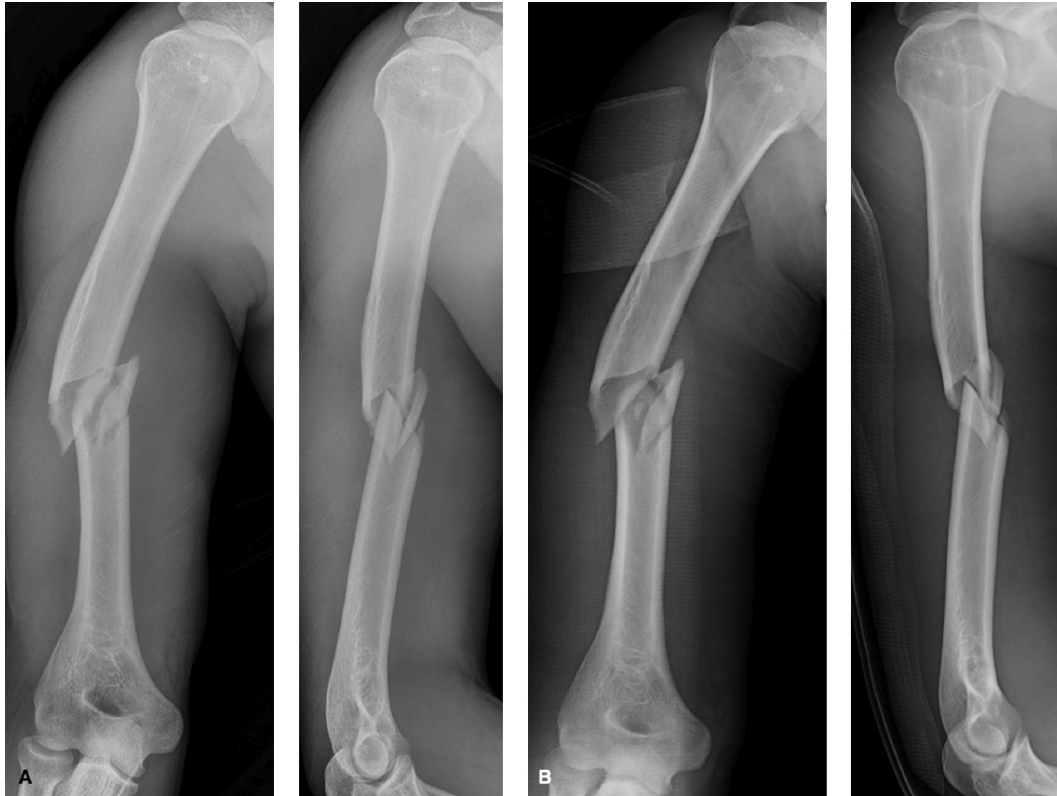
A: Rotation of the distal fragment in the fractured extremity leads to rotation through the fracture site, placing neurovascular structures at risk. B: The splinted arm shows better concomitant rotation of the proximal and distal fragments. A transthoracic view, changing the orientation of the x-ray beam instead of the fractured extremity, would be the safest manner to show orthogonal views of both the proximal and distal fragments.
